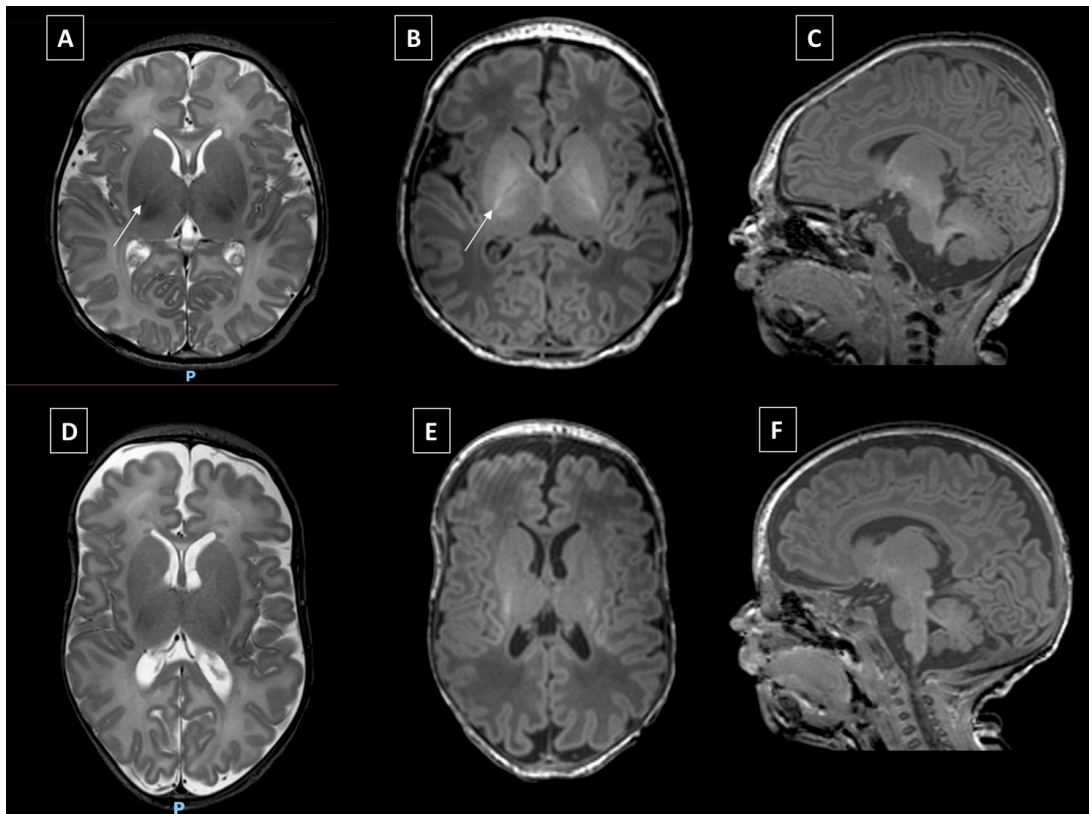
MRI images—term and preterm infant. Representative MRI findings of a term-born and a preterm infant imaged at term-corrected age. Top row: 3T images from a term-born infant born at 41 weeks+4 days and scanned at a postmenstrual age of 42 weeks+1 day. Axial T2 weighted (A), T1 weighted (B) and sagittal T1 (C) weighted images shown. Note the subgaleal collection in the superior parietal convexity. The low T2 and high T1 signal from myelin in the posterior limb of the internal capsule is shown by arrows in A and B. Note also the symmetrical small ventricles and small extracerebral and interhemispheric space in the term-born baby. Lower row (D–F): 3T images from a baby born at 32+3 days and scanned at 40 weeks 5 days. Axial T2 weighted (D), T1 weighted (E) and sagittal (F). Note the scaphocephalic skull shape typical of preterm infants, mildly dilated ventricles, subependymal pseudocysts, probably secondary to a preceding GMH. The myelination is appropriate for age and the basal ganglia structures are unremarkable. In other planes (not seen in these images), punctate white matter lesions are seen. GMH, germinal matrix haemorrhage.
